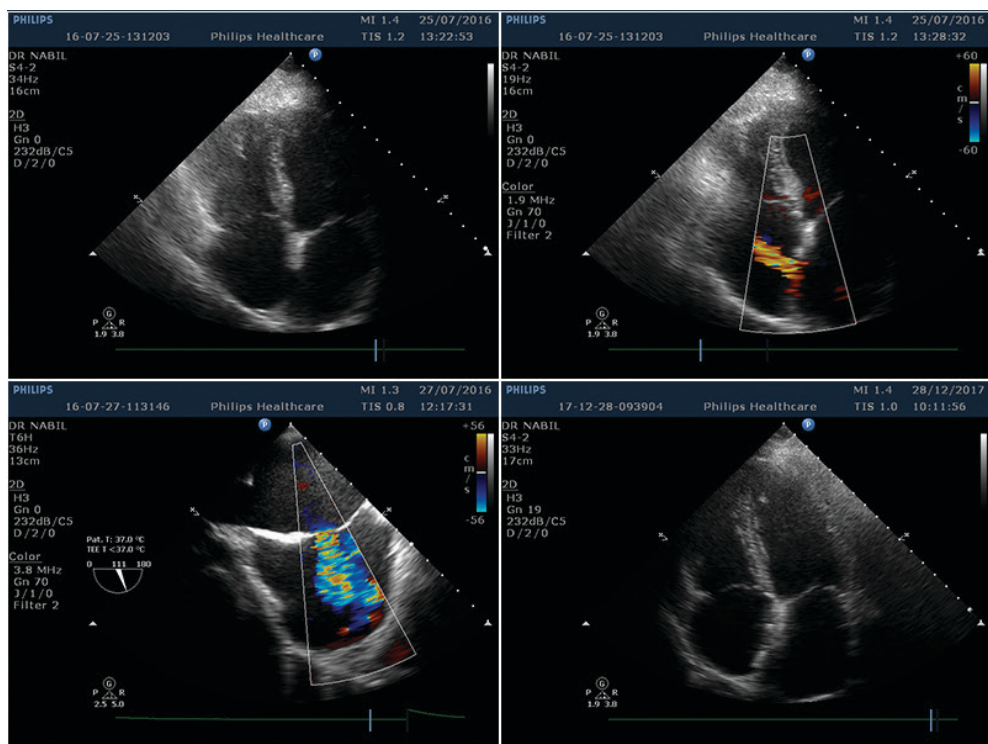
A secundum atrial septal defect (ASD) in 46 years old female patient with left-to-right shunt was confirmed by 2-dimensional transthoracic echocardiogram (TTE) (Panel A), 2-dimensional TTE color Doppler (Panel B). Transesophageal bicaval view with color Doppler (TEE) (Panel C) and TTE echocardiography of the final result after transcatheter closure with Amplatzer occluder (Panel D).
